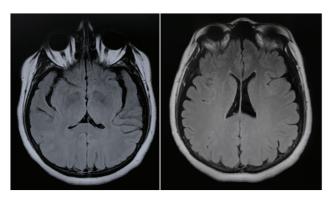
FLAIR-weighted nuclear magnetic resonance imaging showing unaltered ventricular system and brain parenchyma evidencing the absence of hydrocephalus and indicating idiopathic intracranial hypertension.
